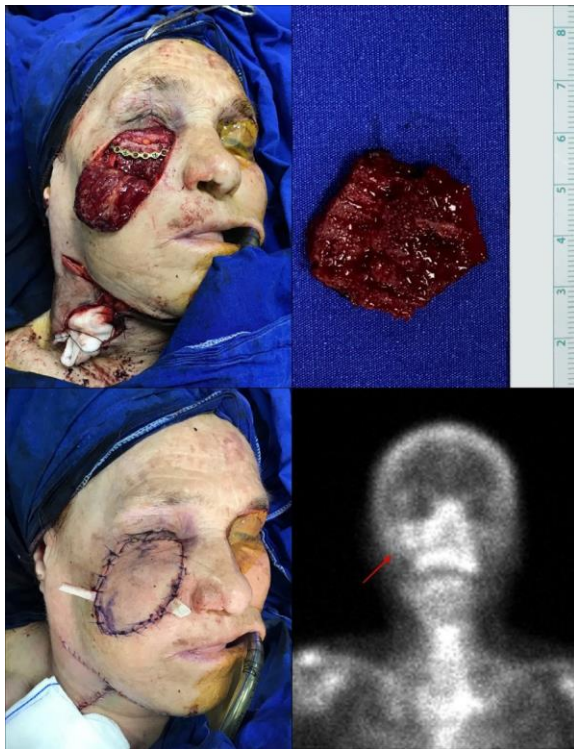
The view of Case 2 is seen after shaping the autologous bone graft by inverting and fixing it with plate screw and before covering with the free flap (Above left). Corticocancellous bone graft harvested with the dimensions 3x3 cm (Above right). The view after completion of the maxillary area reconstruction and neck dissection (Below left). The increase in osteoblastic activity (marked with an arrow) at the upper right maxillary level is observed on bone scintigraphy, three years after the operation (Below right).
